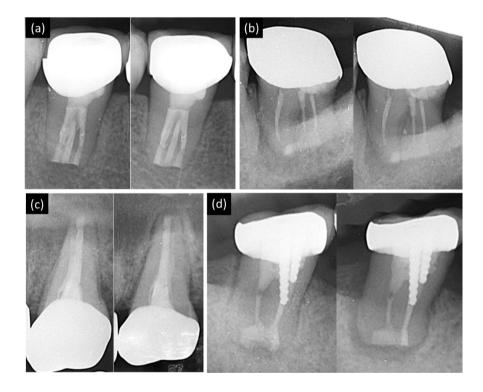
Representative periapical radiographs for each Molven Criteria; (a) Molven 1. Complete healing in tooth #46, (b) Molven 2. Incomplete healing in tooth #37, (c) Molven 3. Uncertain healing in tooth #27, (d) Molven 4. Unsatisfactory healing in tooth #37
